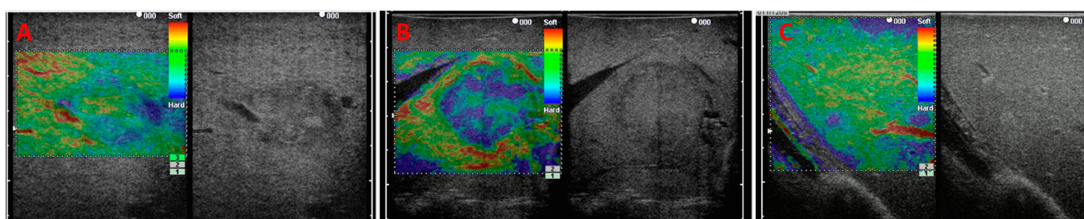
Example of intra-operative elastography of liver. (A) shows elastogram and B-mode ultrasound of a lesion of type 3 showing a mosaic pattern with dominant green areas. (B) shows a tumor with mosaic pattern with dominant blue areas. (C) shows a blue homogeneous lesion with a obscure high-echo in the B-mode scan [155]. Images reproduced with permission of John Wiley and Sons.
